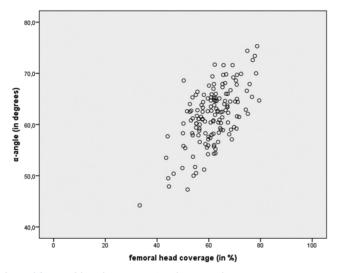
Correlation between α -angle and femoral head coverage in ultrasounds.
